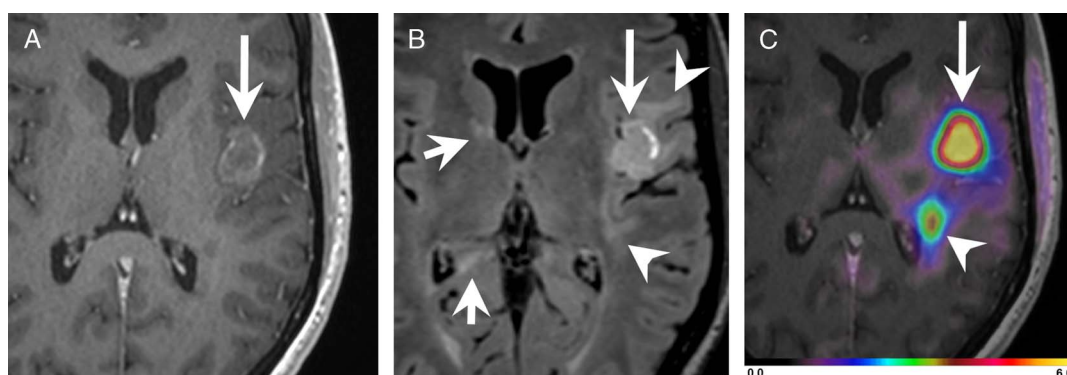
Glioblastoma multiforme in an MS patient. The new appearing lesion in the left-sided insula (arrow) shows some contrast enhancement, predominantly at the rim on the T1-weighted MR image (A). The lesion (arrow) is hyperintense on the FLAIR-weighted MR image (B). In the periphery of the lesion, confluent hyperintense areas (arrowheads) are seen. Focal demyelinations (small arrows) are seen in the internal capsule and subependymal area adjacent to the frontal horn as well as in the parahippocampal gyrus and subependymal area adjacent to the trigone on the right side. FET-PET (C) co-registered with the T1-weighted MR image reveals high uptake of the lesion (arrow, SUV_{max} 6.0, TBR_{max} 5.2) and another small focus posteriorly (arrowhead).
